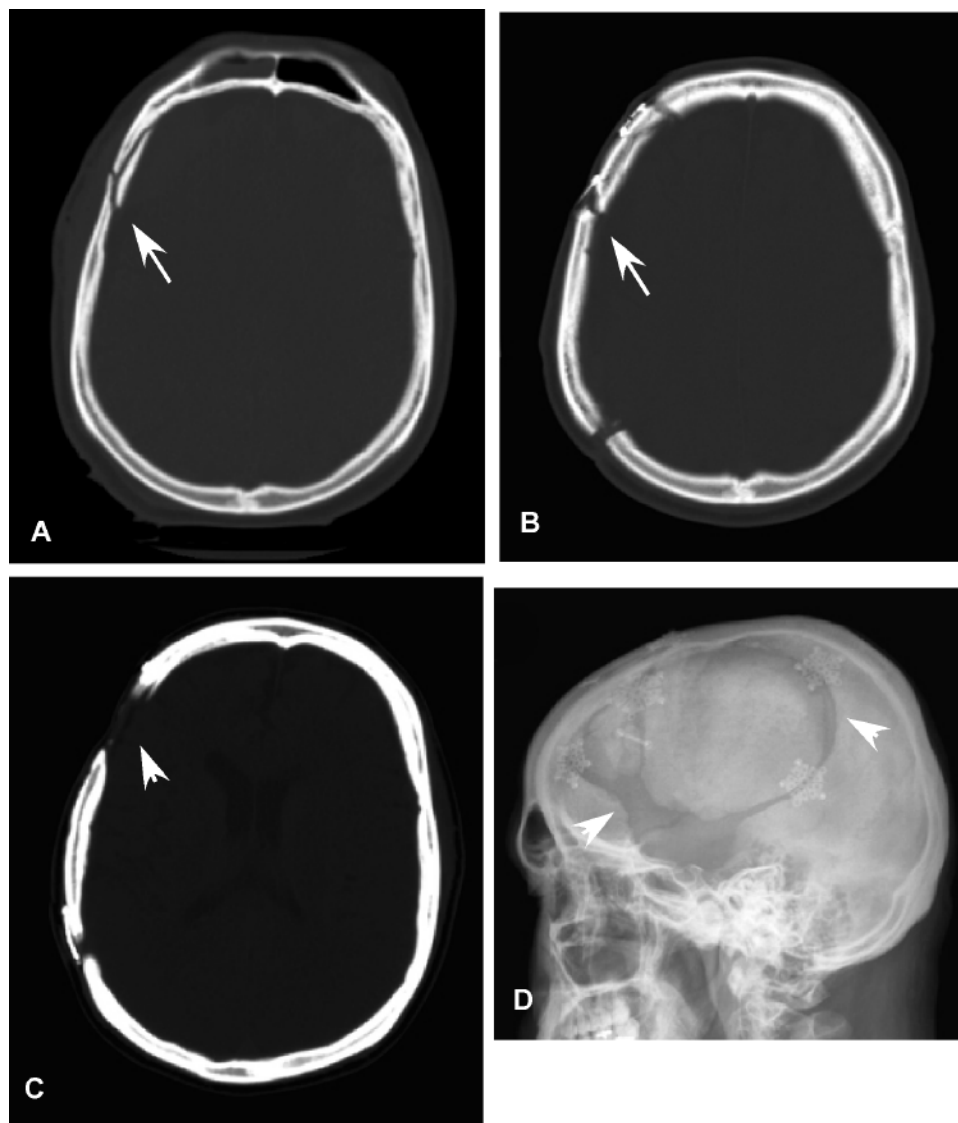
Bone resorption. A: Noncontrast CT image of a frontal skull fracture (*arrow*) in a patient who underwent decompressive craniectomy. B: At 4 months following the decompressive surgery, an autologous cranioplasty repair was performed with plate reconstruction of his skull fracture (*arrow*). C and D: Noncontrast CT scan (C) and lateral plain skull film (D) obtained 2 months after the cranioplasty demonstrating extensive bone resorption of the fractured segment (*arrowheads*). The patient underwent a second cranioplasty with a synthetic bone flap.
